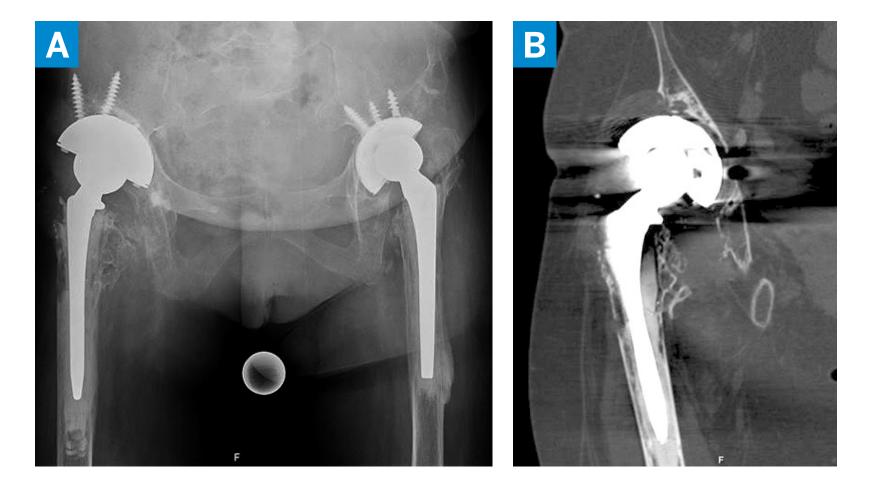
(A) Preoperative radiograph demonstrating a hybrid right THA, with femoral stem cement mantle fracture, metallic debris, and periacetabular radiolucency in all Charnley zones. (B) CT reconstruction revealing complex bony defects and a Paprosky IIIA acetabular defect and a Paprosky IIIA/IIIB femoral defect.
